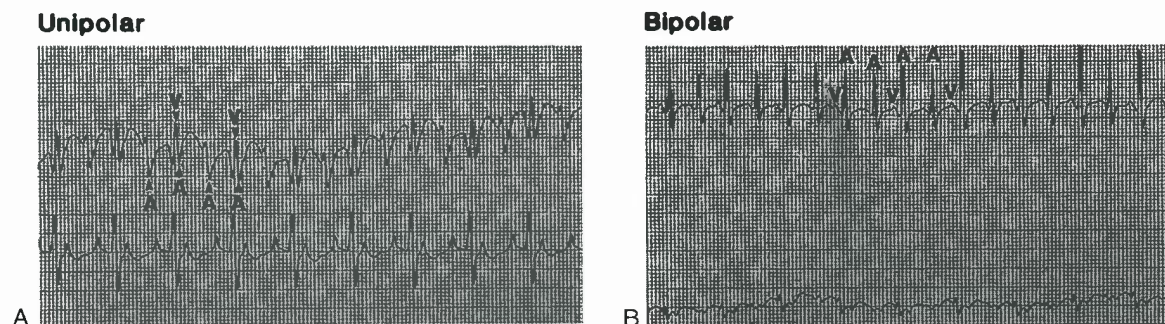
Two transesophageal recordings (50 mm/s) in a 2,250-g newborn with atrial flutter (150-ms atrial cycle length) and 2:1 AV block showing a comparison of unipolar (A) and bipolar (B) recordings. Note that the prominent ventricular electrogram and the wandering baseline in the unipolar recording are eliminated in the bipolar recording. Therefore, the atrial electrogram is better delineated in the bipolar recording.
